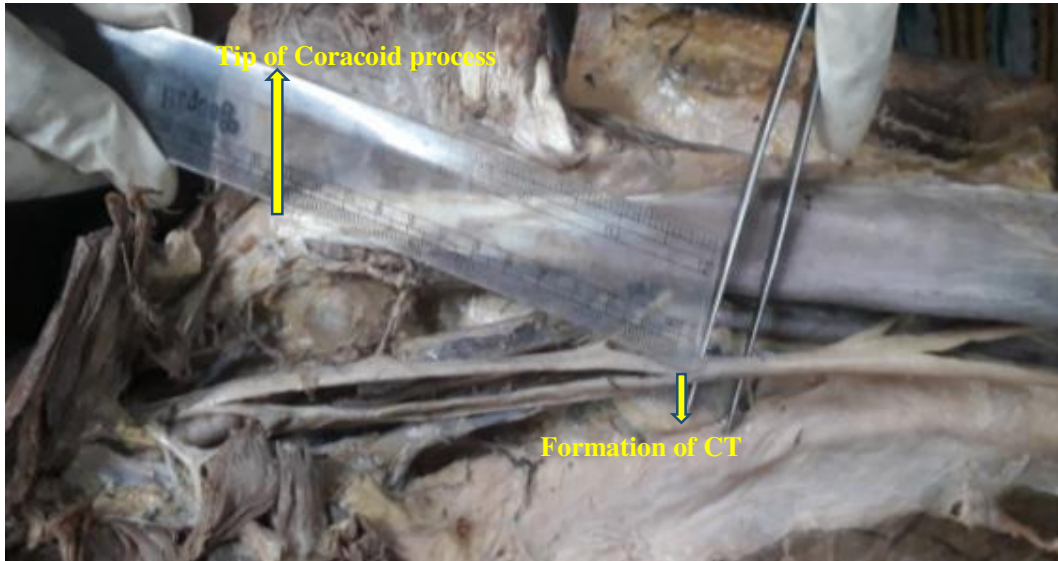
showing distance (12.2 cm) from the tip of coracoid process to the formation of CT (Common trunk).
